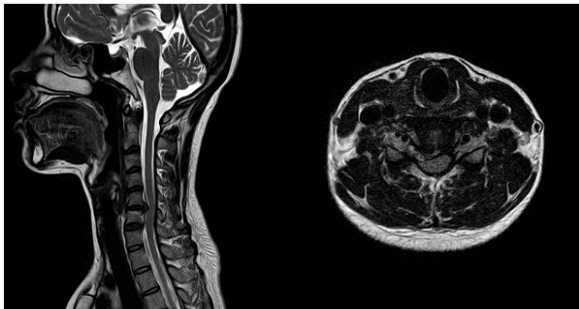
T2-weighted sagittal and T2 weighted axial magnetic resonance images from initial presentation
